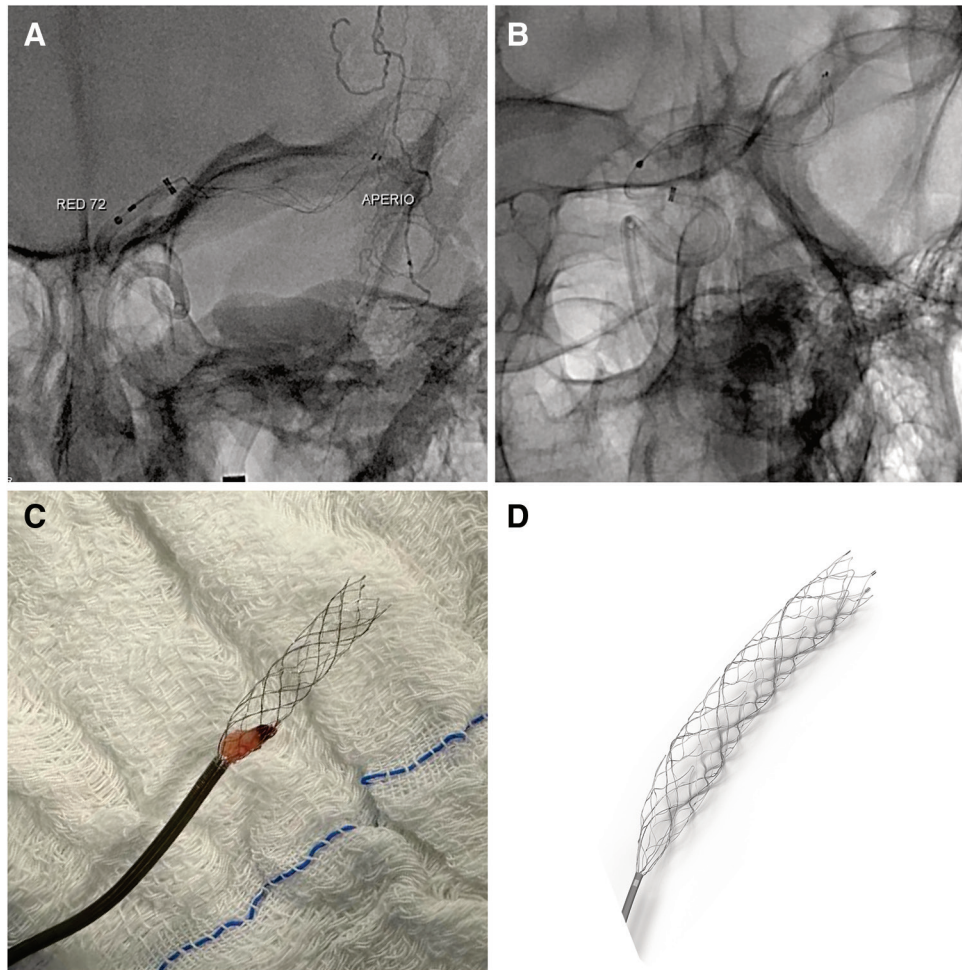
X-ray images of the Aperio Hybrid device (Acandis, Pforzheim, Germany) and an aspiration catheter (RED 72; Penumbra, Alameda, CA, USA) during thrombectomy of an M1 occlusion (A) and a carotid tip occlusion (B). A photo (C) shows a thrombus captured by the Aperio Hybrid and the RED catheter. A magnified photo of the Aperio Hybrid and its unique design (D)
